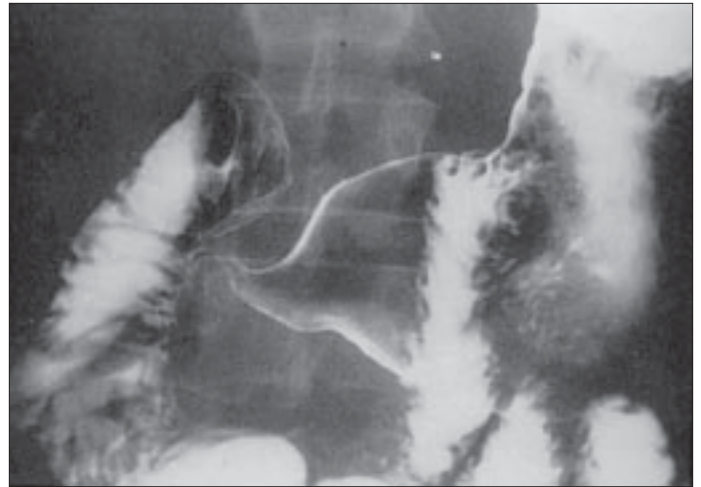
A double-contrast radiograph showing the "ram's horn" sign, a characteristic finding in gastroduodenal Crohn's disease. Reproduced with permission from reference 13.
